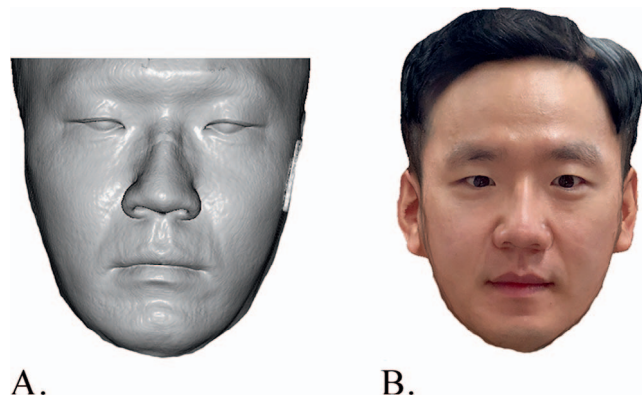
To integrate the facial scan into CBCT images, they were exported to the following respective file formats: (A) STL file for CBCT soft-tissue image; (B) OBJ file for facial scan.
